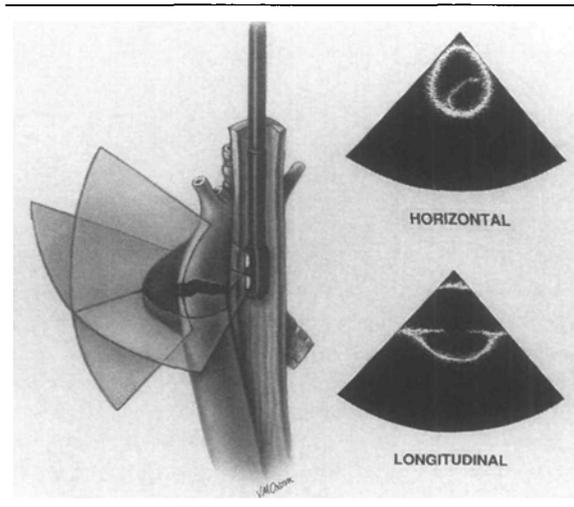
Traumatic aortic disruption. *Left hand panel:* The biplane TEE probe is seen in the esophagus. Orthogonal ultrasound planes image the descending aorta, which has a traumatic tear and false aneurysm. *Right hand panel:* the horizontal and longitudinal ultrasound images, which demonstrate a flap of tissue within the aortic lumen.
